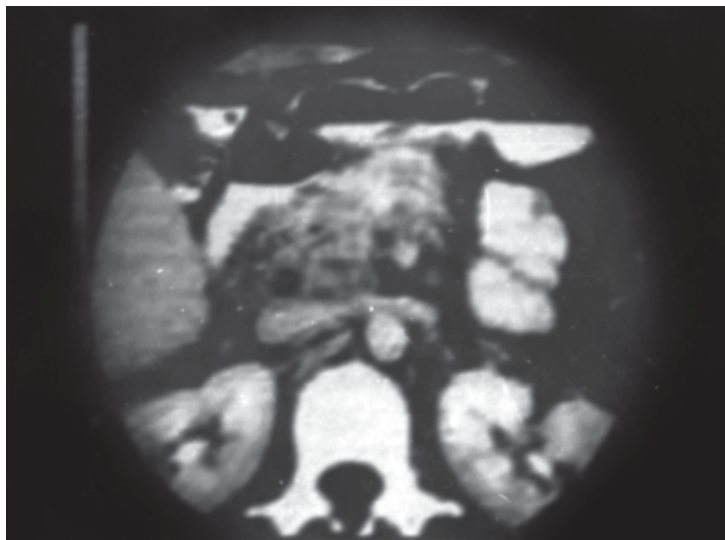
Pancreatic tuberculosis. CT scan shows multiple nodules in the pancreatic area. In addition, there is enlargement of peripancreatic lymph nodes also
